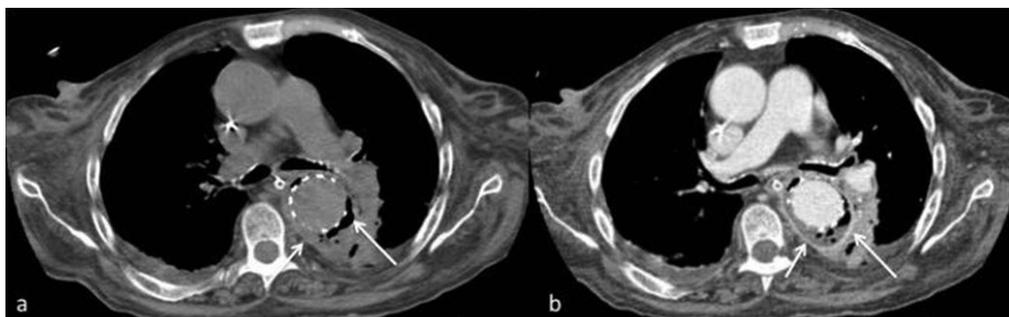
Unenhanced (A) and contrast-enhanced (B) axial thoracic CT images about 1 month after thoracic endovascular aortic repair show peri-graft soft tissue thickening with microbubbles of gas surrounding the aortic prosthesis (arrows) and suggesting peri-graft infection. There are no signs of endoleaks.
